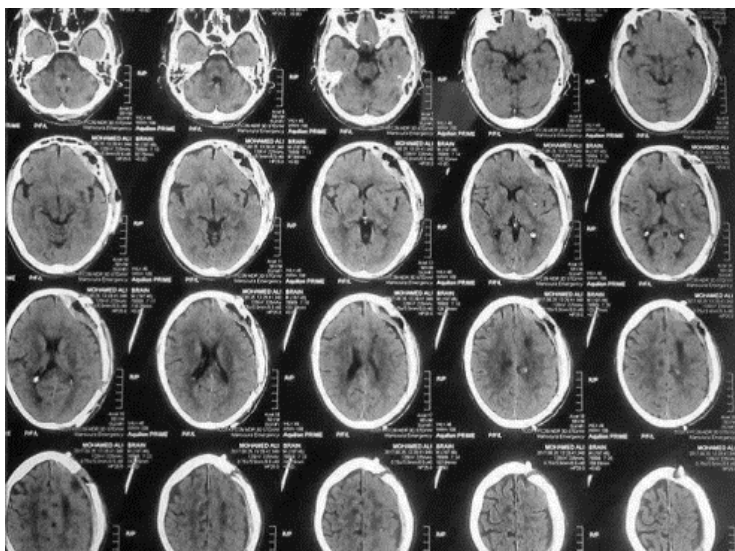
Post-operative CT brain explaining large EDH with bony erosion and extra dural lesion totally removed
